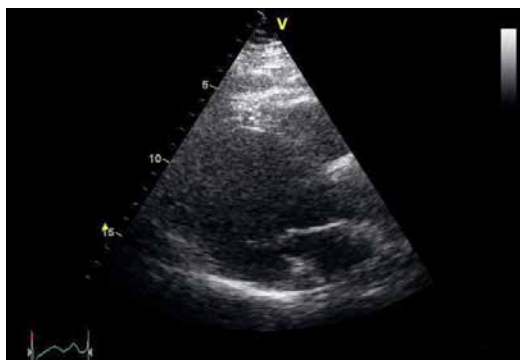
Echocardiogram (parasternal view) showing dilated and globally hypokinetic LV.
